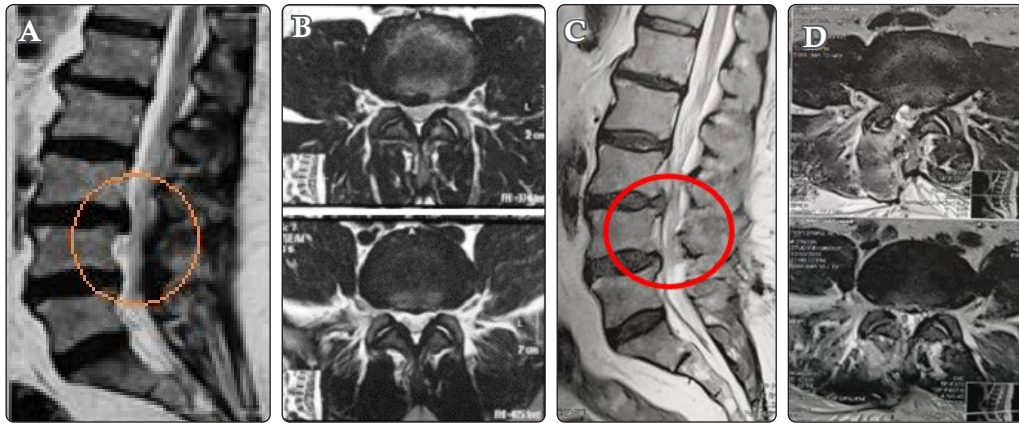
A case of L3-L4 and L4-L5 stenosis undergoing laminotomy. (A) Preoperative MRI sagittal view. (B) Preoperative MRI axial view. (C) Postoperative MRI sagittal view. (D) Postoperative MRI axial view.
